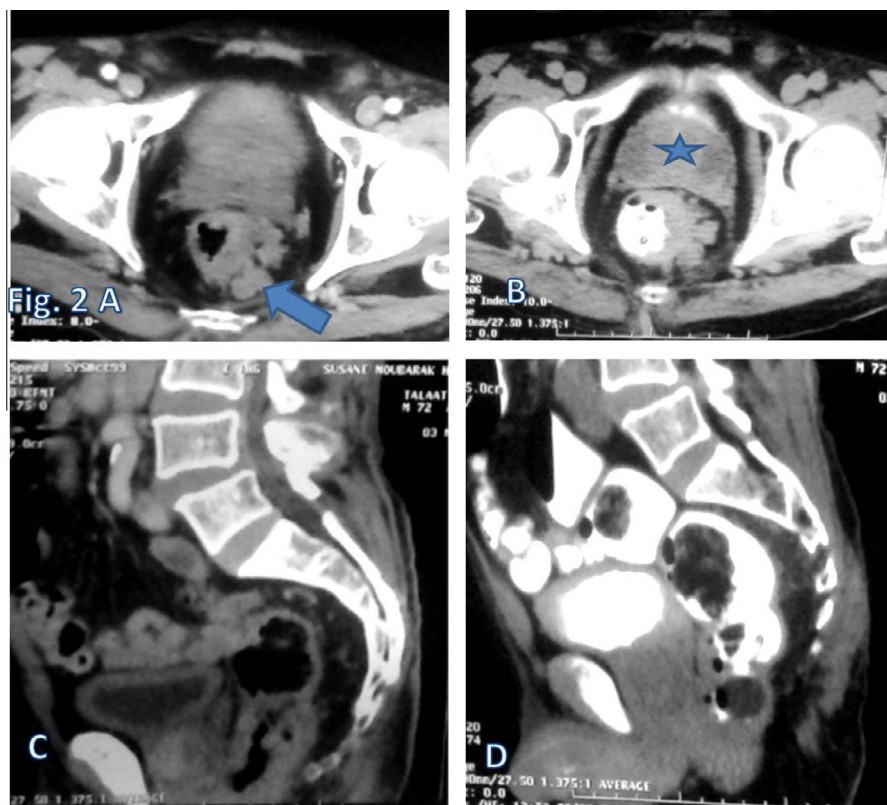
72 year old male patient: Axial CT MPR image with only oral contrast (A) revealed irregular thickening of the Lt. lateral rectal wall with peri-rectal enlarged LNs (arrow). After endorectal contrast (B) the lesion became more defined with irregular eccentric filling defect and haziness of the peri-rectal fat planes. Sagittal MPR image with oral contrast only (C) revealed the irregular rectal wall thickening that encroaches on rectal lumen after endorectal contrast (D) The rectum became fully distended with contrast and the lesion appeared more obvious with evident proximal shouldering. Also, the lesion appeared inseparable from the prostate anteriorly.
